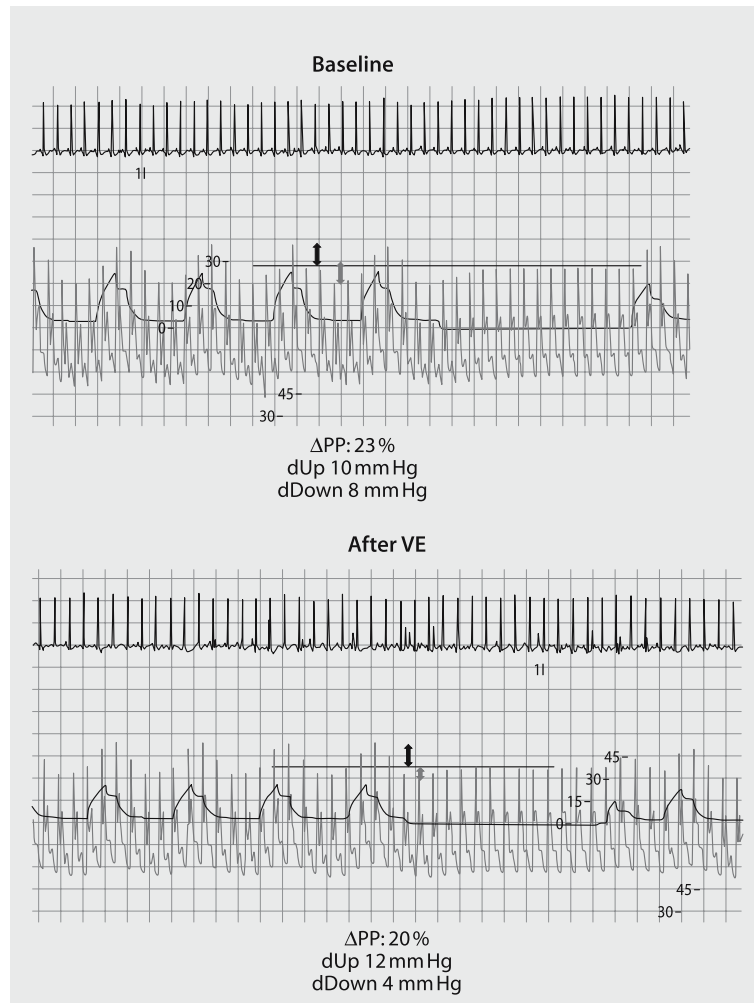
Significant pulse pressure variations ( $\Delta PP$ ) related to acute cor pulmonale in two patients (a, b) ventilated for severe acute respiratory distress syndrome. Echocardiography demonstrated marked right ventricular dilatation leading to marked restriction of the left ventricle. After volume expansion (VE),  $\Delta PP$  was not corrected and cardiac index (CI) was not increased. Note that patient b was receiving a norepinephrine infusion. RA: right atrium; LA: left atrium; RV: right ventricle; LV: left ventricle
